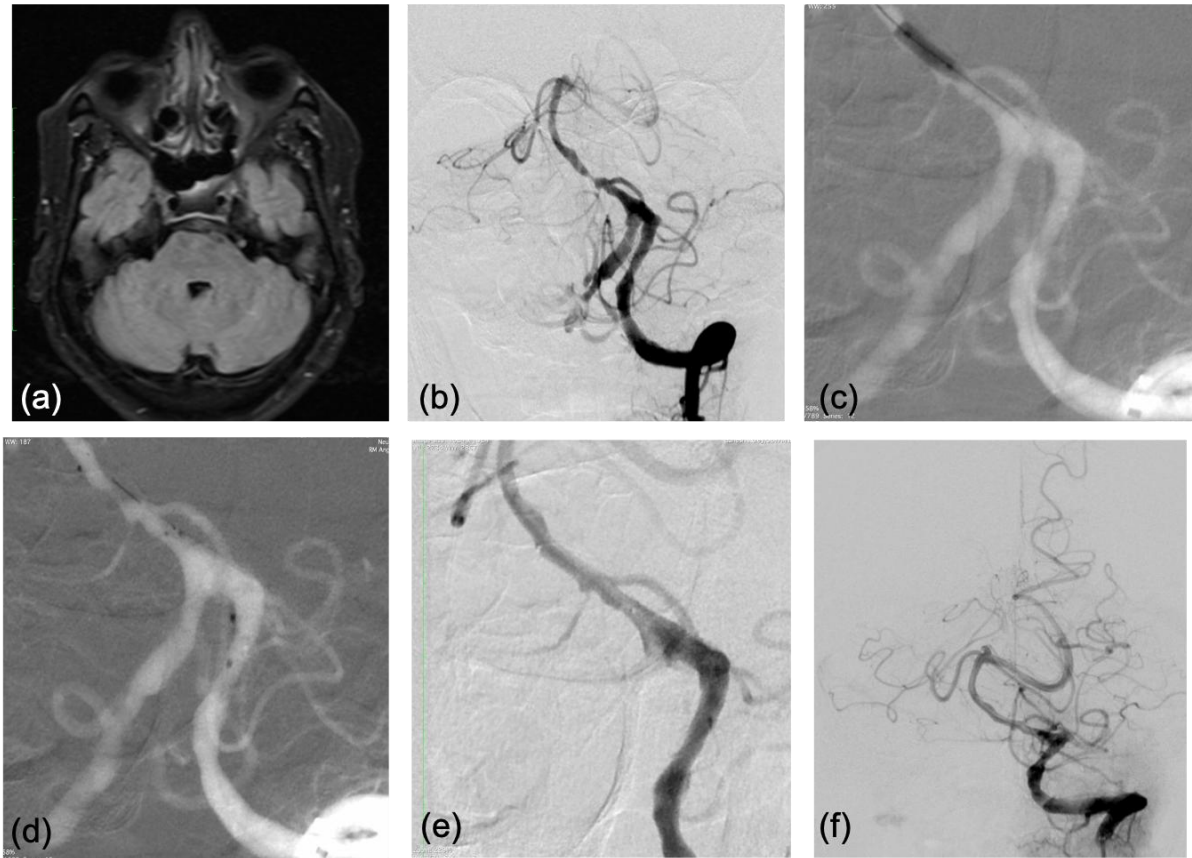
53-year-old male presented with 3 episodes of TIA (a) FLAIR image axial shows no evidence of infarct. (b) Left vertebral artery injection AP view shows critical stenosis of mid basilar artery with poor flow in the distal intracranial circulation. (c) Road map with pre-stenting dilatation of the stenosed segment. (d) Road map acquisition during stent placement. (e) & (f) AP injection after stenting shows stent in situ with normalization of caliber of the basilar artery and good intracranial flow from the left vertebral artery.
